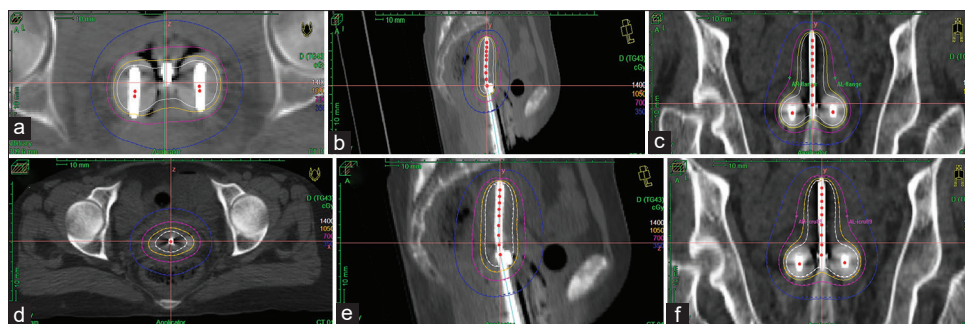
In treatment planning systems 700cGy (100%) dose prescribed to manchester Point A (A_{flange}) and ICRU-89 Point A (A_{icru89}) (a and d) Axial, (b and e) Sagittal, (c and f) Coronal computed tomography images with isodose level of 50%, 100%, 150% and 200% of prescribed dose i.e. 350 cGy, 700 cGy, 1050 cGy and 1400 cGy for A_{flange} and A_{icru89} Plans. V_d = Isodose volume (cm^3) receiving d dose, $d = X$ percent of prescribed dose in cGy, $X = Is$ a value for which isodose volume is to be calculated
